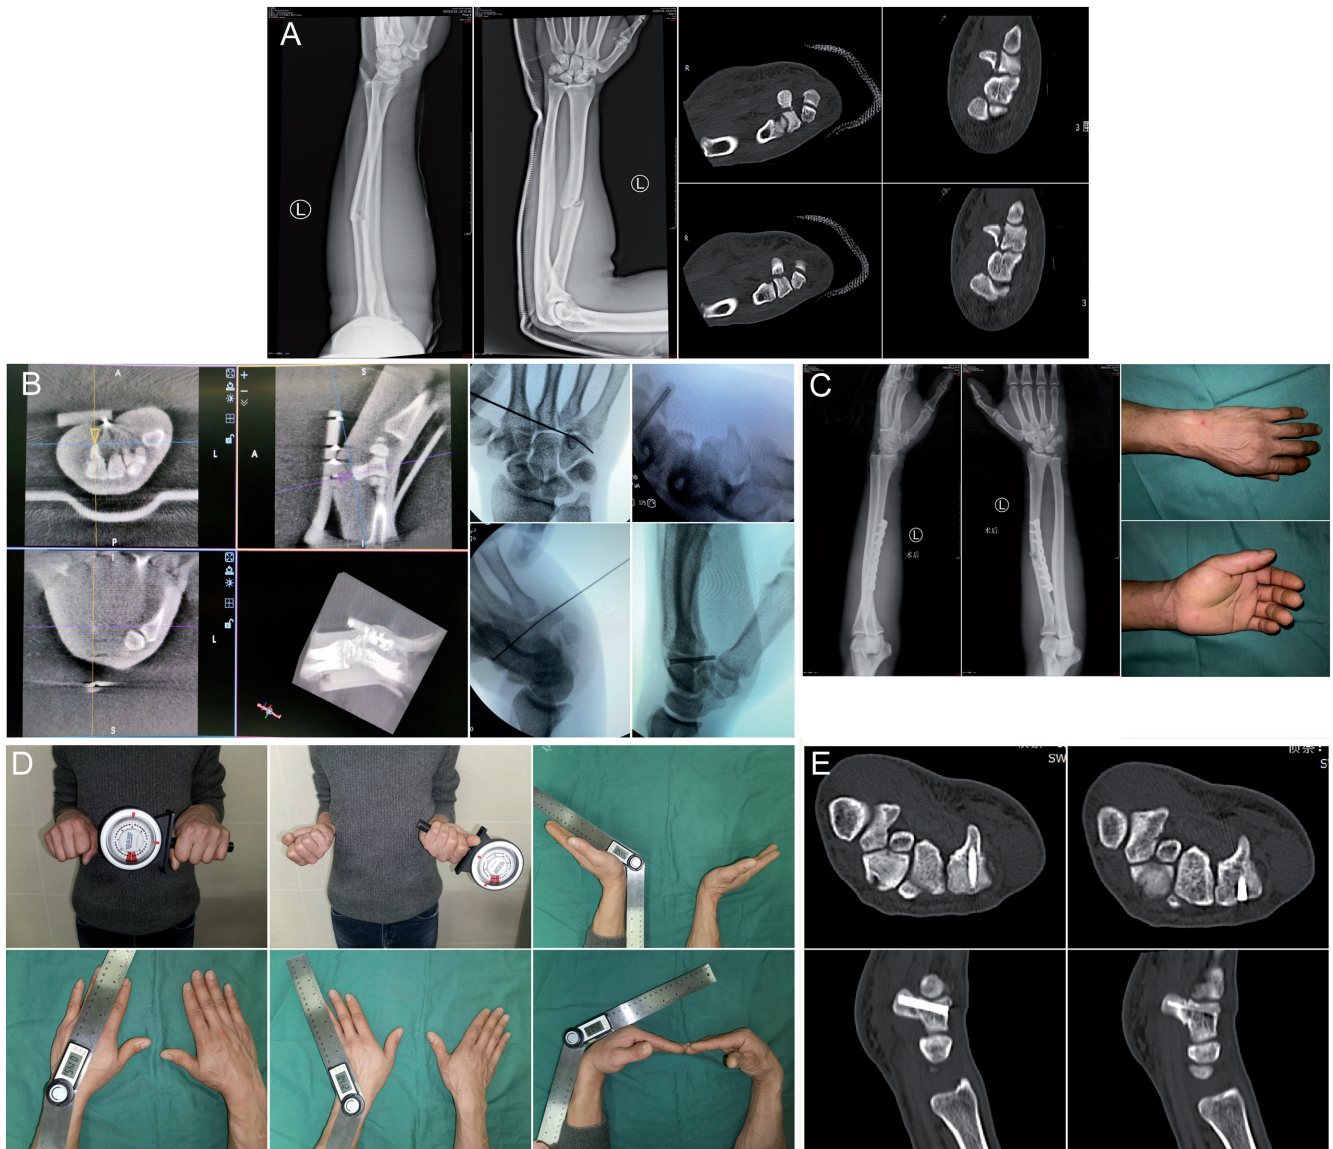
A-E. The 37-year-old man whose left arm was caused a bruise injury by a heavy object and underwent the closed reduction percutaneous internal fixation under the TiRobot navigation in our center. The X-ray film and CT images of the patient of the preoperation (A). Intraoperative guidance K-wire was inserted into the fragments and then the headless compression screw was inserted into the hook through the trajectory with robot navigation. (B). The X-ray immediately after operation and the appearance of the hand (C). After follow-up for 9 months, the function and appearance recovered satisfactory (D), and the CT images of the hook of the hamate fracture healing. (E). CT, computerized tomography.
